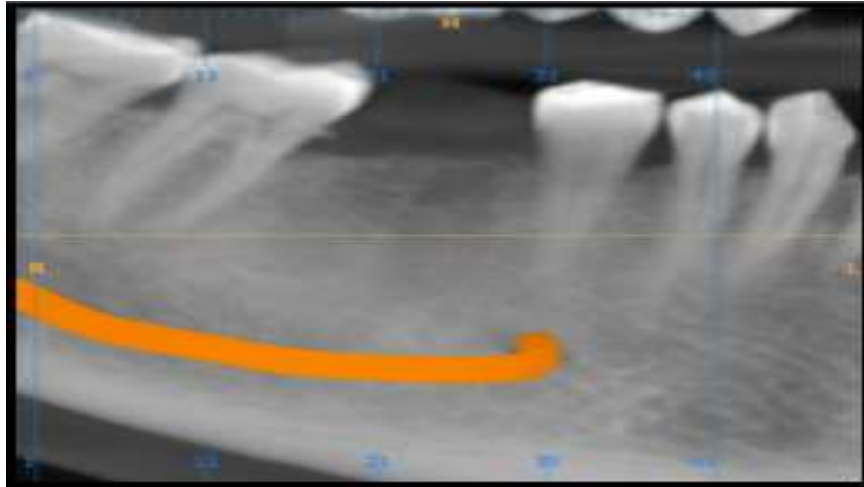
Pre-operative CBCT, 46 Region
